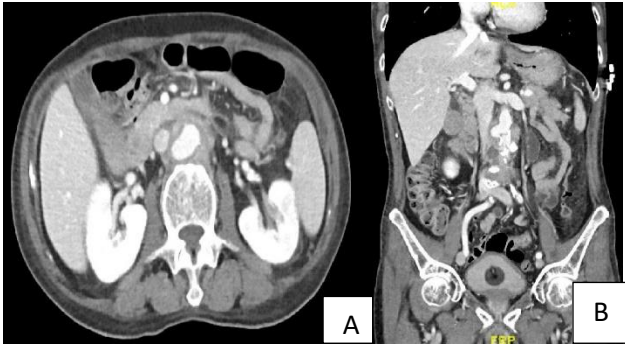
(A and B): Axial and coronal view on CTA showing the focal outpouching of contrast from the right posterolateral wall of the infrarenal aorta concerning an aneurysm with a contained rupture. The aneurysm is surrounded by an oval, 3-cm, low-density structure, with a contrast blush and peripheral rim enhancement along with retroperitoneal and perinephric fat stranding.
